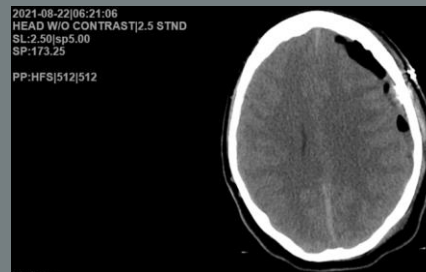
On 8/20/21 patient had left side craniotomy and evacuation of subdural hematoma. The CT Head on the right, shows the results 2 days later. "In-situ drainage catheter is present. Small amount of subdural air hemostatic material present. There is persistent mild mass effect"
